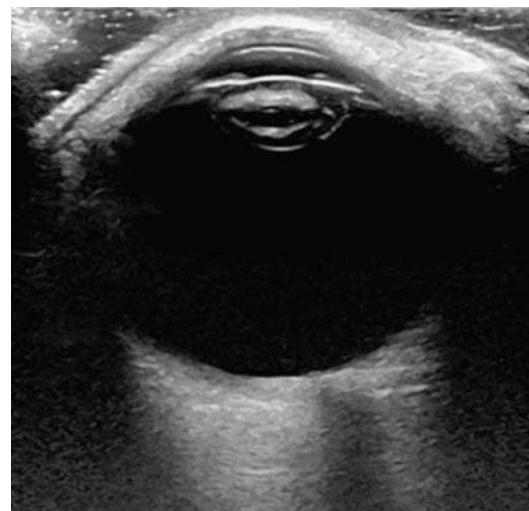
B-scan ultrasonography showed high reflection of lens cortex, clear vitreous body, and stable fundus before operation
